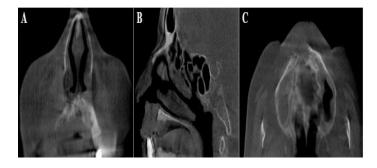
Bone destruction and lesion area in the buccal and palatal alveolar crest observed in CBCT sections
